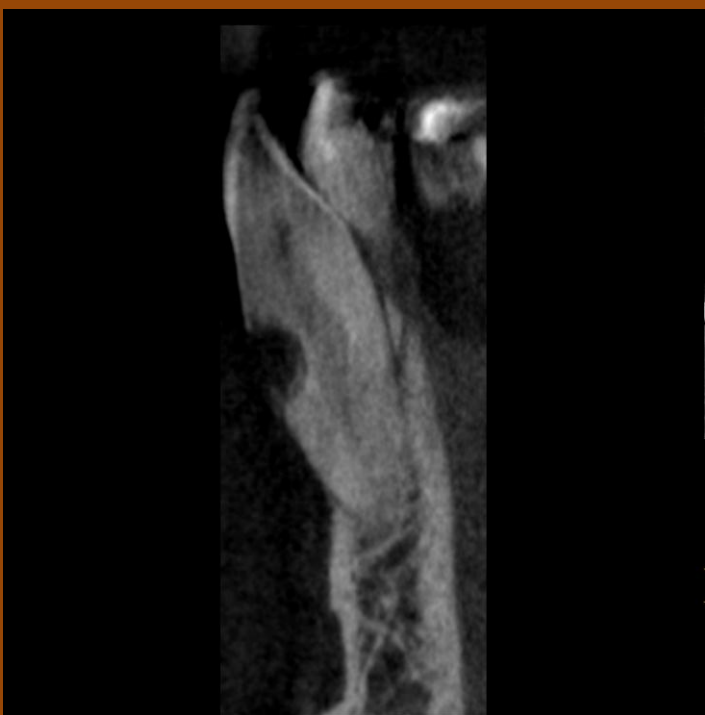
CBCT showing the extent of resorption defect.
